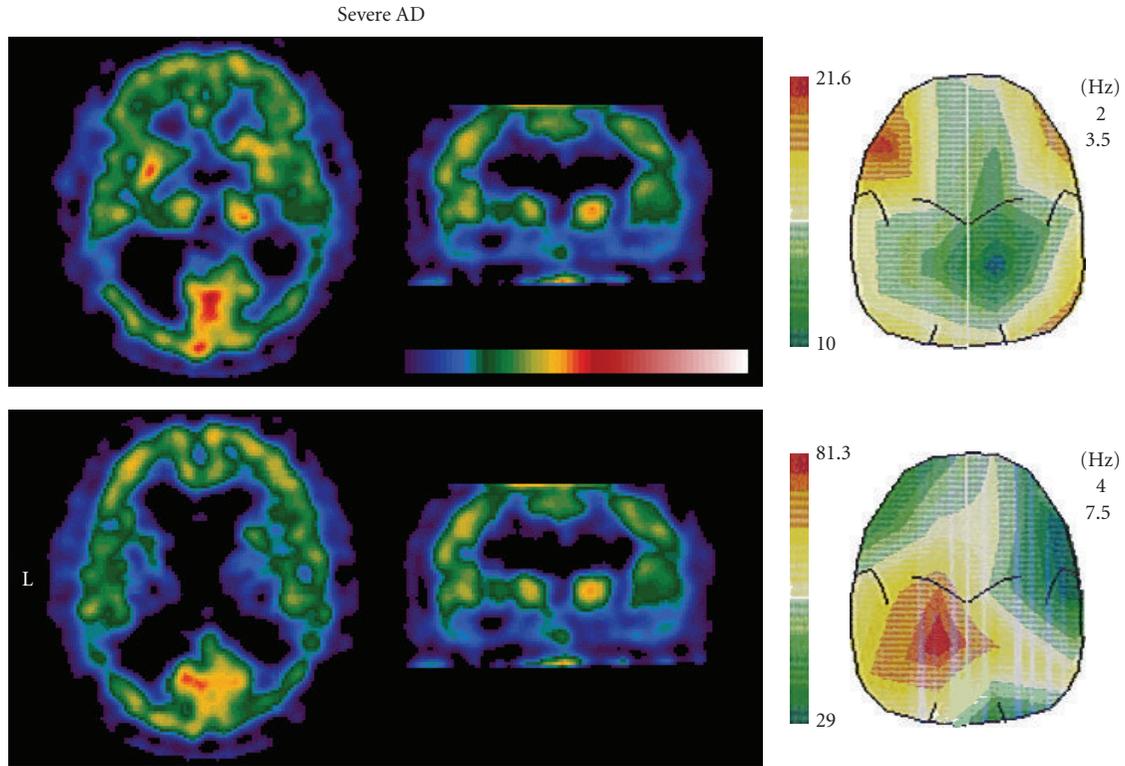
Sample of SPECT neuroimaging (Tc-99 HMPAO) and EEG brain mapping in a severe AD patient. Topographic scalp distribution of the EEG power on the 2.0 to 3.5 Hz frequency band (top right) and 4.0 to 7.5 Hz frequency band (bottom right) is shown. For more details, see text.
